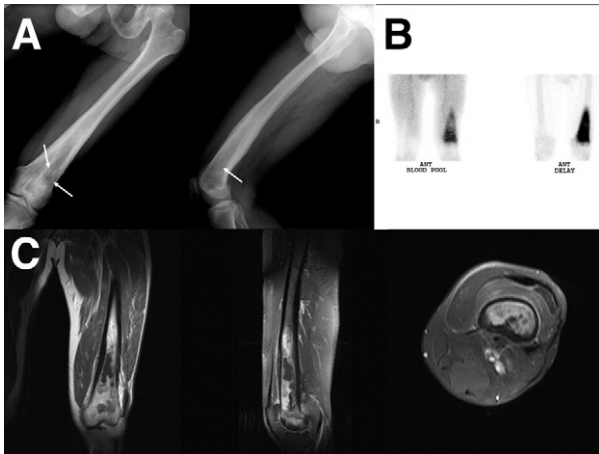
(A) Radiographs showed thickening of the cortex, reactive sclerosis, and focal destruction of the medullary portion. (B) The 3-phase bone scan showed increased uptake in all 3 phases. (C) MRI scans showed patchy bone marrow replacing the soft-tissue signal intensity and thickened bony cortex with surrounding inflammatory extension. (arrows, sequestrum; R, right; ANT, anterior.)
